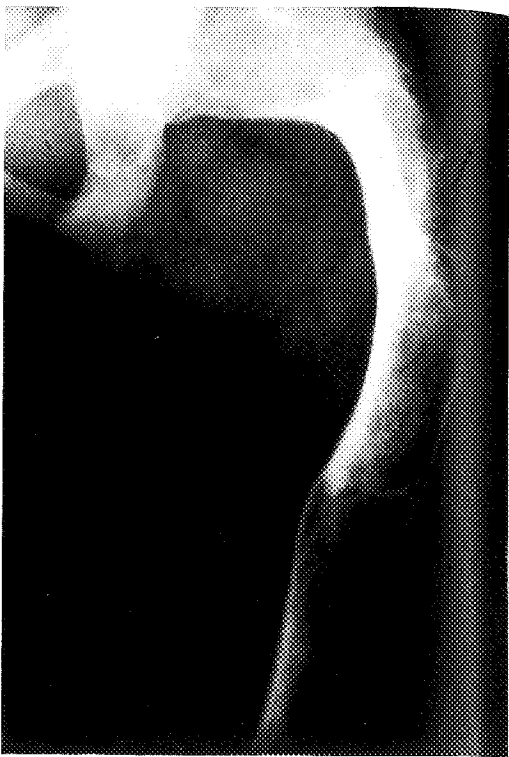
Radiograph of the femur, showing the classic "shepherd's crook" deformity of fibrous dysplasia.
